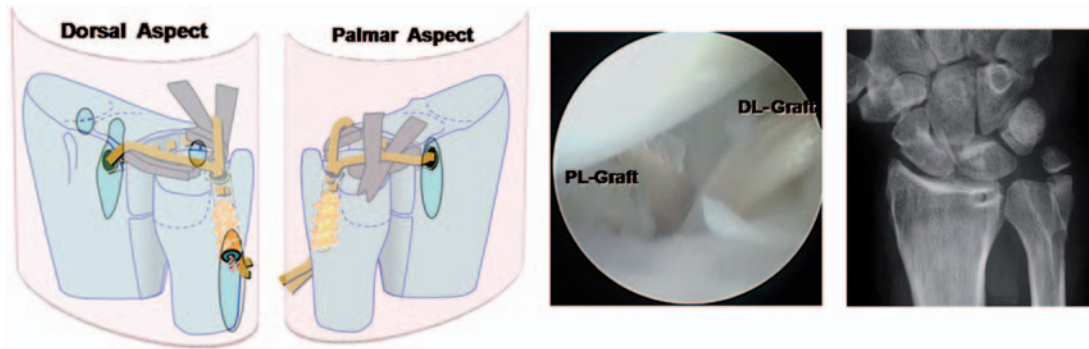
An interference screw is used to fix the tendon graft under proper tension and restore stability of the ulno-carpal and the distal radioulnar joint. At the end of the procedure, arthroscopy shows both palmar (PL-Graft) and dorsal limb of the tendon graft (DL-Graft) converging towards the fovea. Plain X-rays show proper tunnel positioning.
